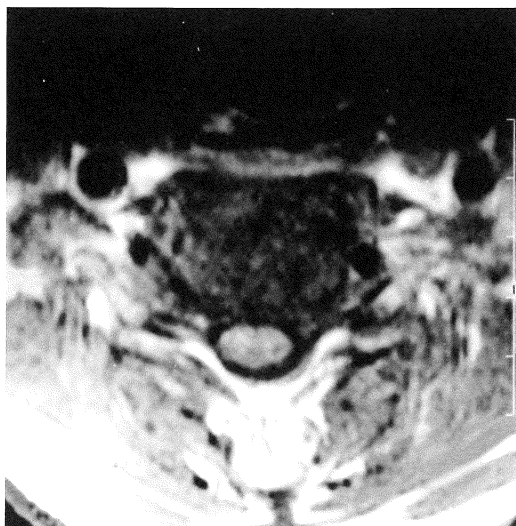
MRI cervical spine (axial view) on 10-11-1996: C6 vertebra shows hypointense signal on T1 enhanced after contrast compatible with vertebral osteomyelitis.
